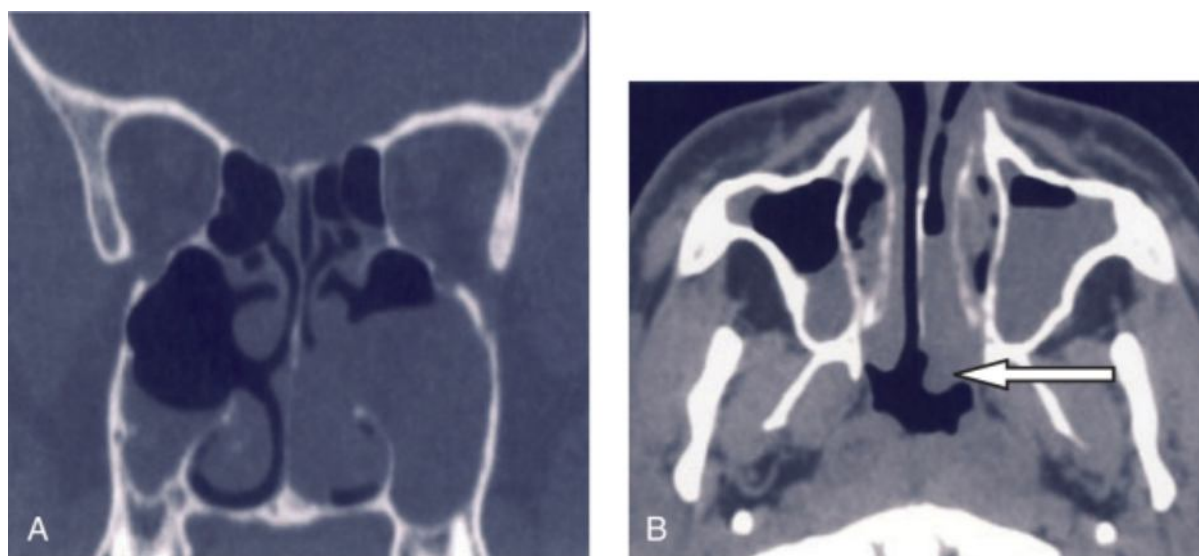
Computed tomography scan demonstrating an antrochoanal polyp from a left opaque antrum into the nose on a coronal image (A) and extending into the nasopharynx on an axial image (B) (*arrow*).
